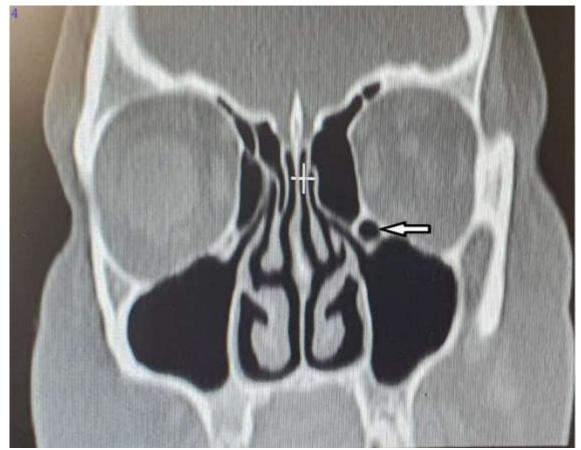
Coronal CT image of a patient showing left Haller cell (arrow)
